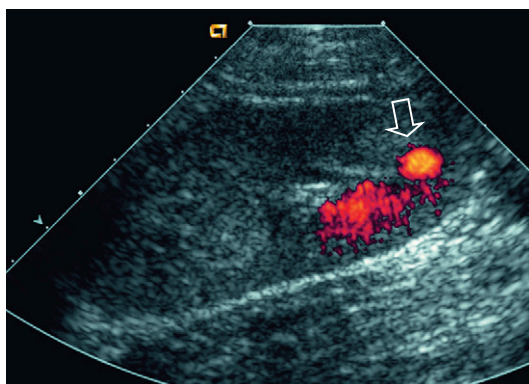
(a) Power Doppler image of a renal transplant approximately 2 weeks after biopsy. A burst of colour is seen overlying the lower pole (arrow). This flash artefact, due to tissue vibration, suggests an underlying arteriovenous fistula. (b) Spectral Doppler tracing obtained at the fistula site reveals a turbulent, high-velocity arterial waveform; that differentiates it from pseudoaneurysm that has to-and-fro flow.
